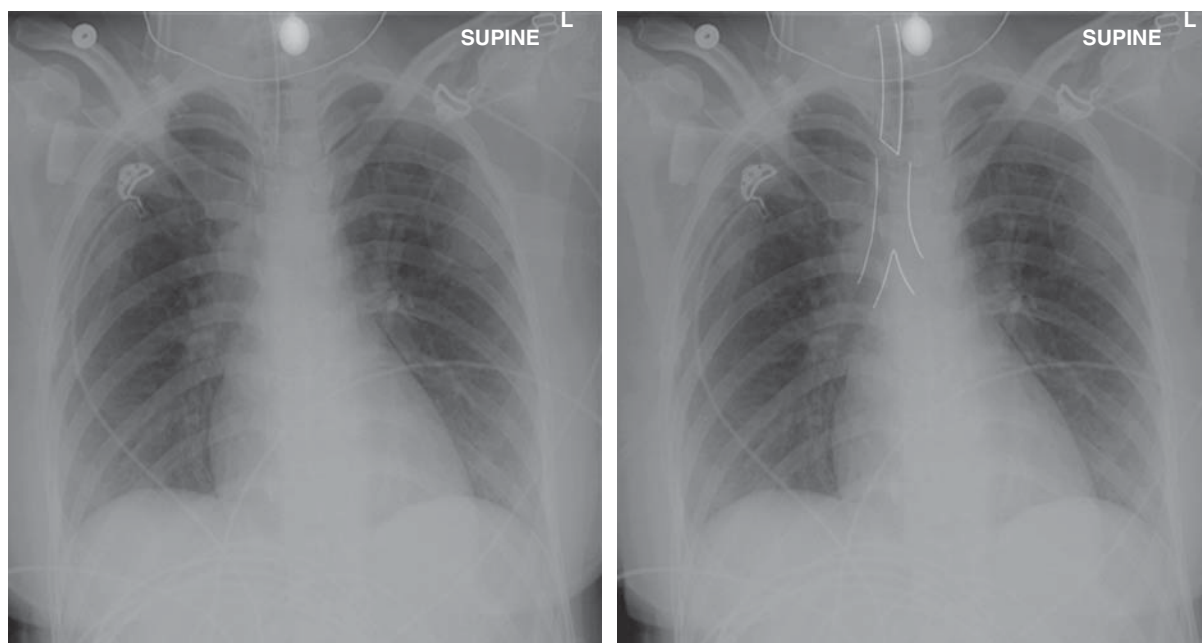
Endotracheal tube positioned too high. Portable anteroposterior chest radiograph of a 24-year-old woman intubated as a result of anaphylactic shock. The endotracheal tube is 5.5 cm above the carina.
